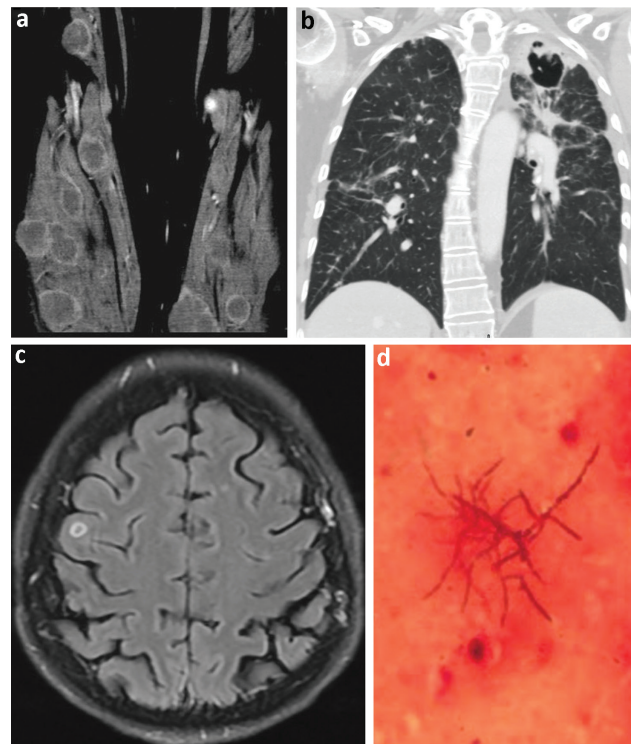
a) Coronal computed tomography section of the limbs, showing multiple subcutaneous and muscular abscess. b) Coronal computed tomography section of the lungs, showing left upper lobe cavitary lesion. c) Axial magnetic resonance imaging of the brain, showing a frontal lobe small ring enhanced lesion. d) Filamentous Gram-positive branching rods on chocolate agar.
